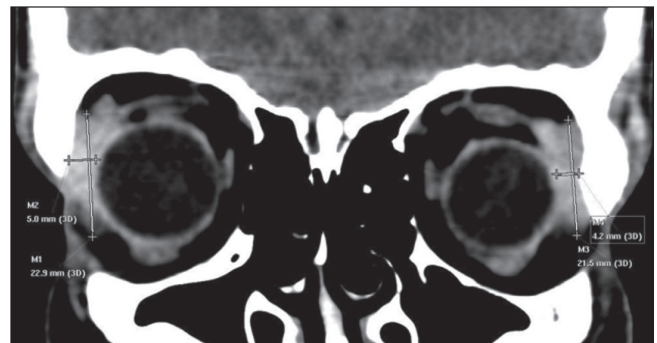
Coronal CT reformat of the lacrimal glands showing the craniocaudal diameters (lines M1 and M3) and coronal plane transverse diameters (lines M2 and M4)
